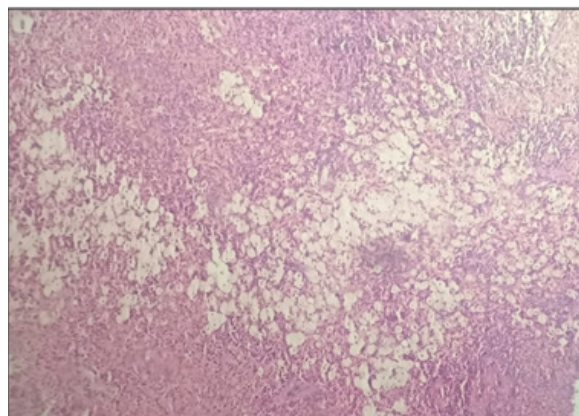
Foamy macrophages in periapical granuloma
